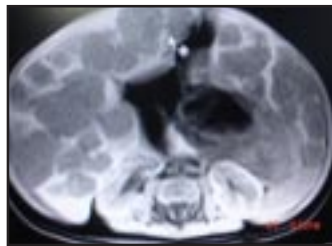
MRI showing enlarged liver with smooth outline & multiple well rounded SOL.
